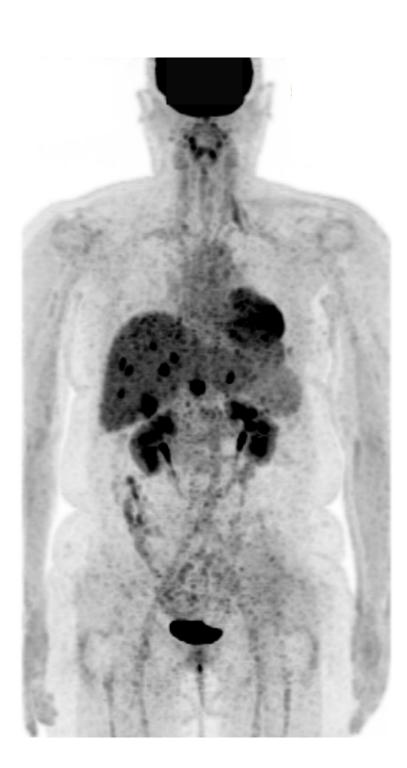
Imaging Findings : PET-CT scans demonstrating extensive metastases to the liver, peritoneum, and lymph nodes in a 41-year-old patient with hormone receptor-positive breast cancer. Disease progression despite standard therapy prompted further genomic investigation.
